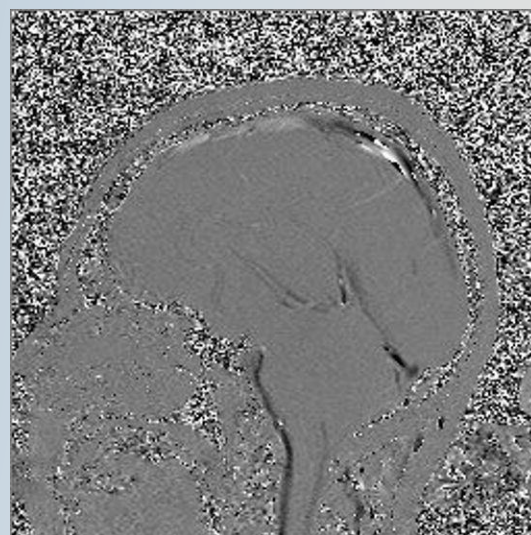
Phase-contrast Cine-MRI study shows a disorganized CSF pulsation, with reduced flow through the posterior part of foramen magnum.
